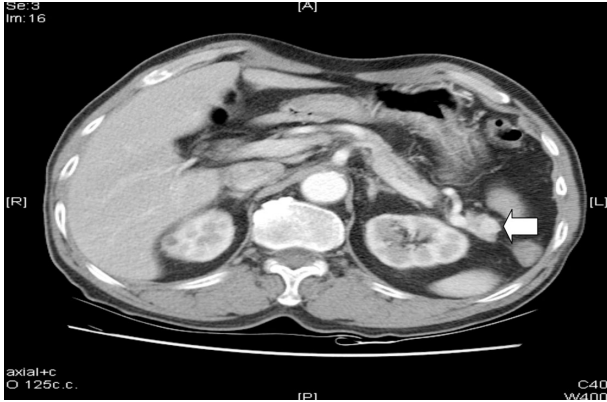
Abdominal CT scan. It showed a hypervascular nodule about 1 cm over pancreatic tail during arterial phase (arrow head).
